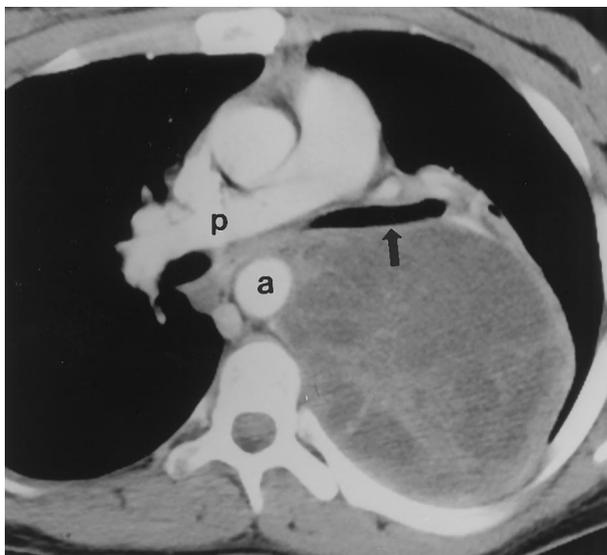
Contrast-enhanced chest CT (mediastinal windows) at the level of the right pulmonary artery (p) in a 23-year-old woman with neurofibromatosis and chest pain. A large, spherical MTNSO encases and displaces the descending aorta (a), produces mass effect on the left upper lobe bronchus (arrow), and demonstrates heterogeneous low attenuation with variable enhancement.
